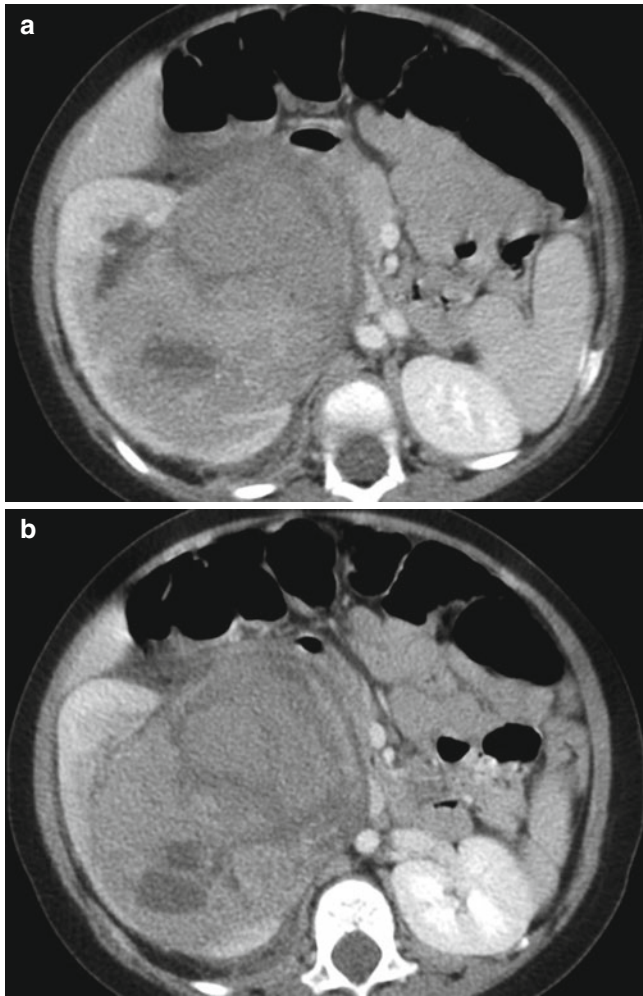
Wilms tumor in a 1-year-old girl. (a and b) Contrast-enhanced CT scans show a heterogeneous mass arising from the renal sinus of the right kidney. The mass shows heterogeneous enhancement and irregular central necrosis and hemorrhage. The mass involves the renal sinus
